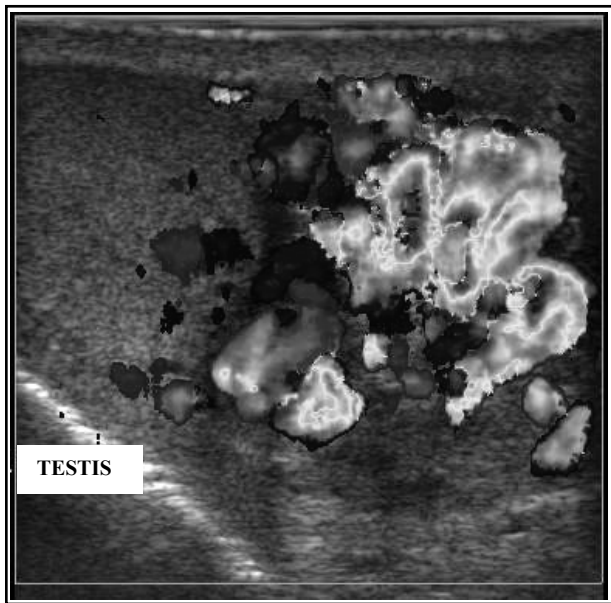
Color Doppler US showed that reflux venous flow increased during Valsalva's maneuver.
